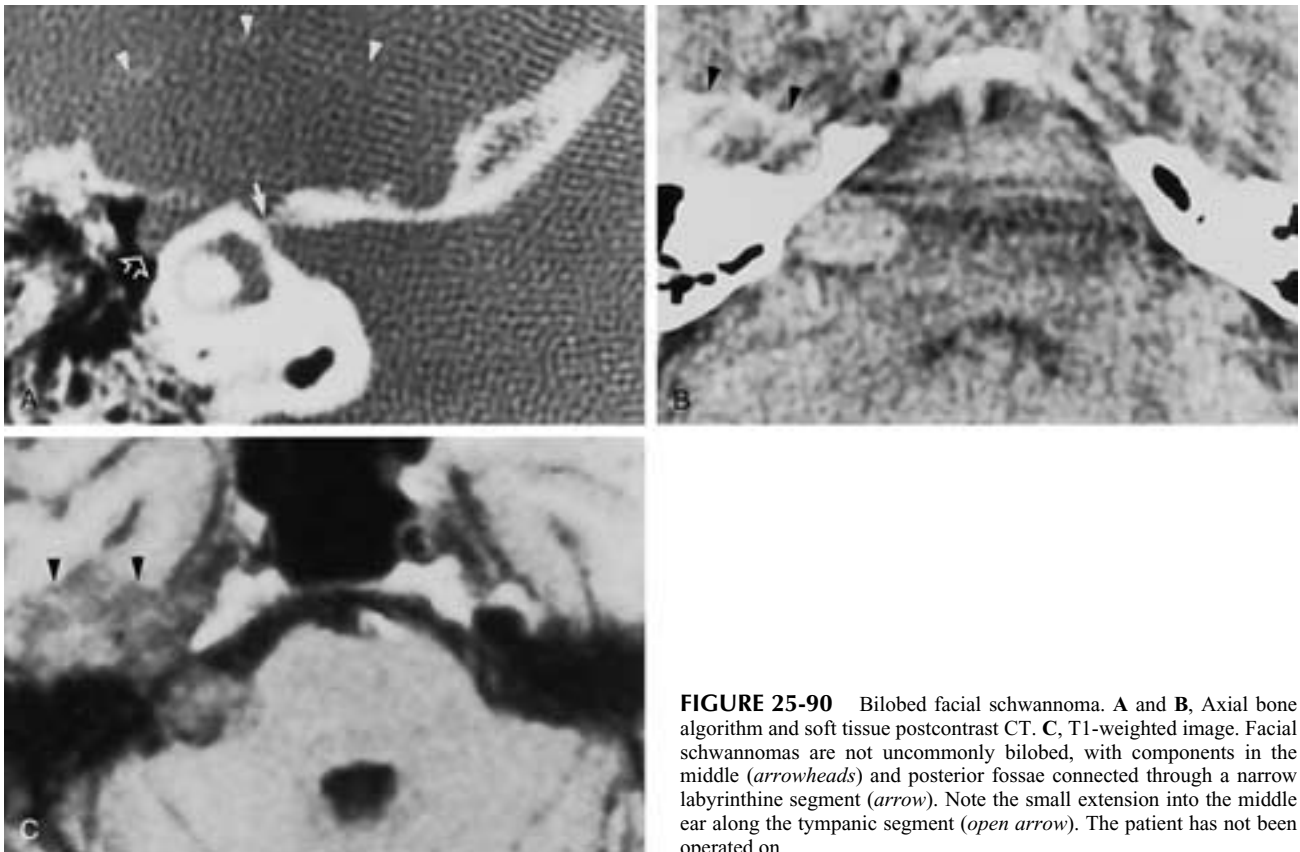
Bilobed facial schwannoma. A and B, Axial bone algorithm and soft tissue postcontrast CT. C, T1-weighted image. Facial schwannomas are not uncommonly bilobed, with components in the middle (arrowheads) and posterior fossae connected through a narrow labyrinthine segment (arrow). Note the small extension into the middle ear along the tympanic segment (open arrow). The patient has not been operated on.
